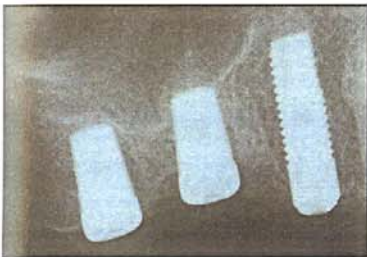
Immediate postoperative radiograph showing 4 x 13 mm Astra ST implant at site #5 and 5 x 7mm Endopore implants at sites #3 & 4. Note minimal sinus floor elevation with sinus floor infrafracture only and no grafting.
